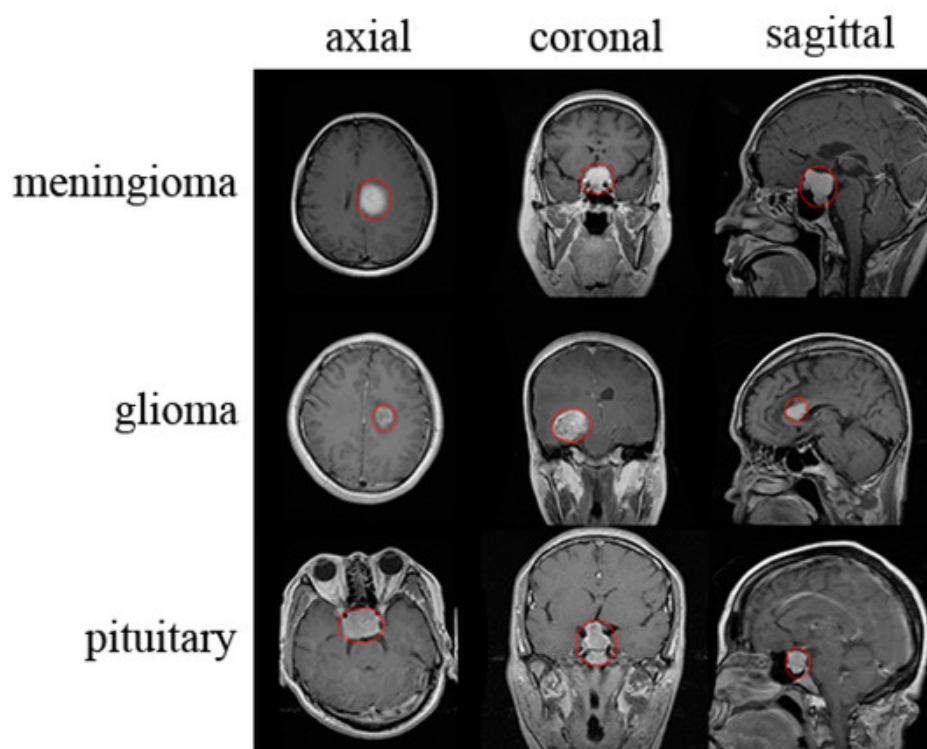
MRI scans showing different tumor types in various planes, with tumors outlined in red.
